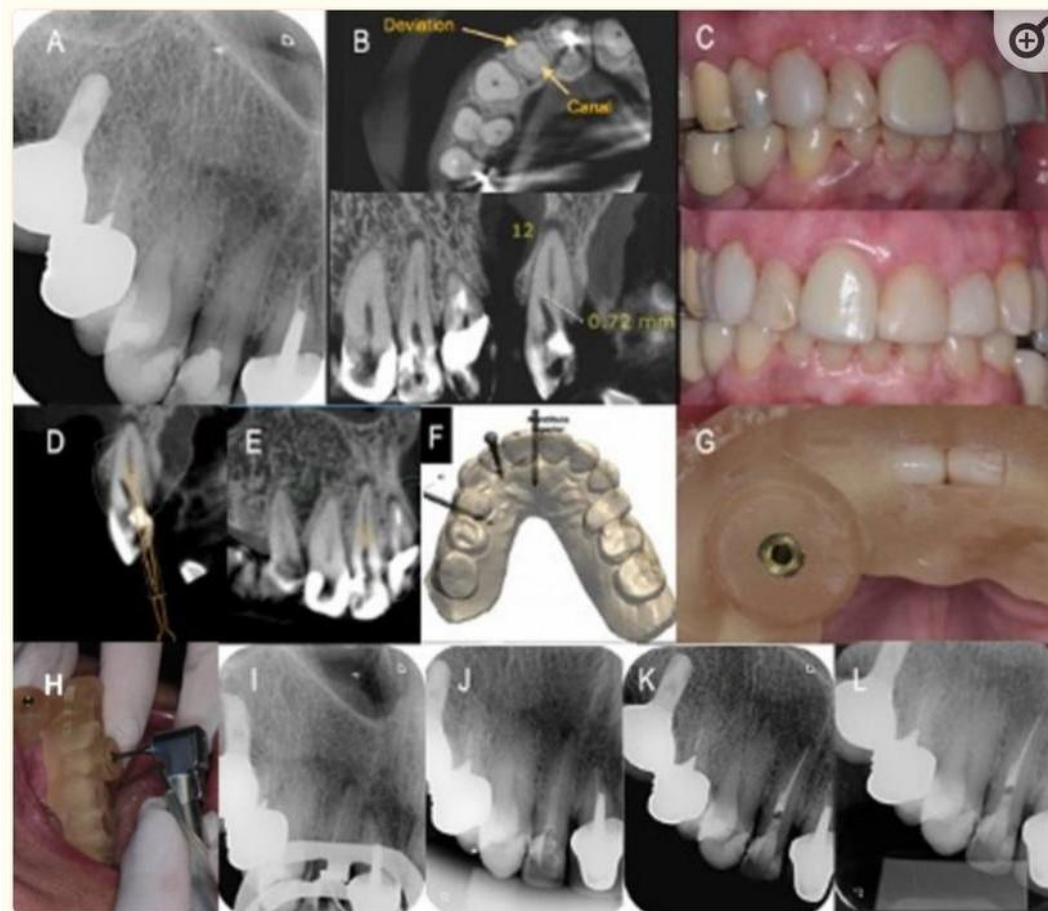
A) Preoperative radiographic image showing partial obliteration and periapical bone resorption; B) CBCT axial, coronal and sagittal images showing periapical bone resorption, partial obliteration of the root canal and buccal deviation; C) Discolored maxillary lateral incisor: frontal and lateral views; D, E, F) 3D root canal planning; G, H) The prototyped surgical guide; I) #15 K file in the working length; J) Intracanal dressing with calcium hydroxide after instrumentation; K) The final radiograph; L) The radiograph at 12-month follow up[112]
